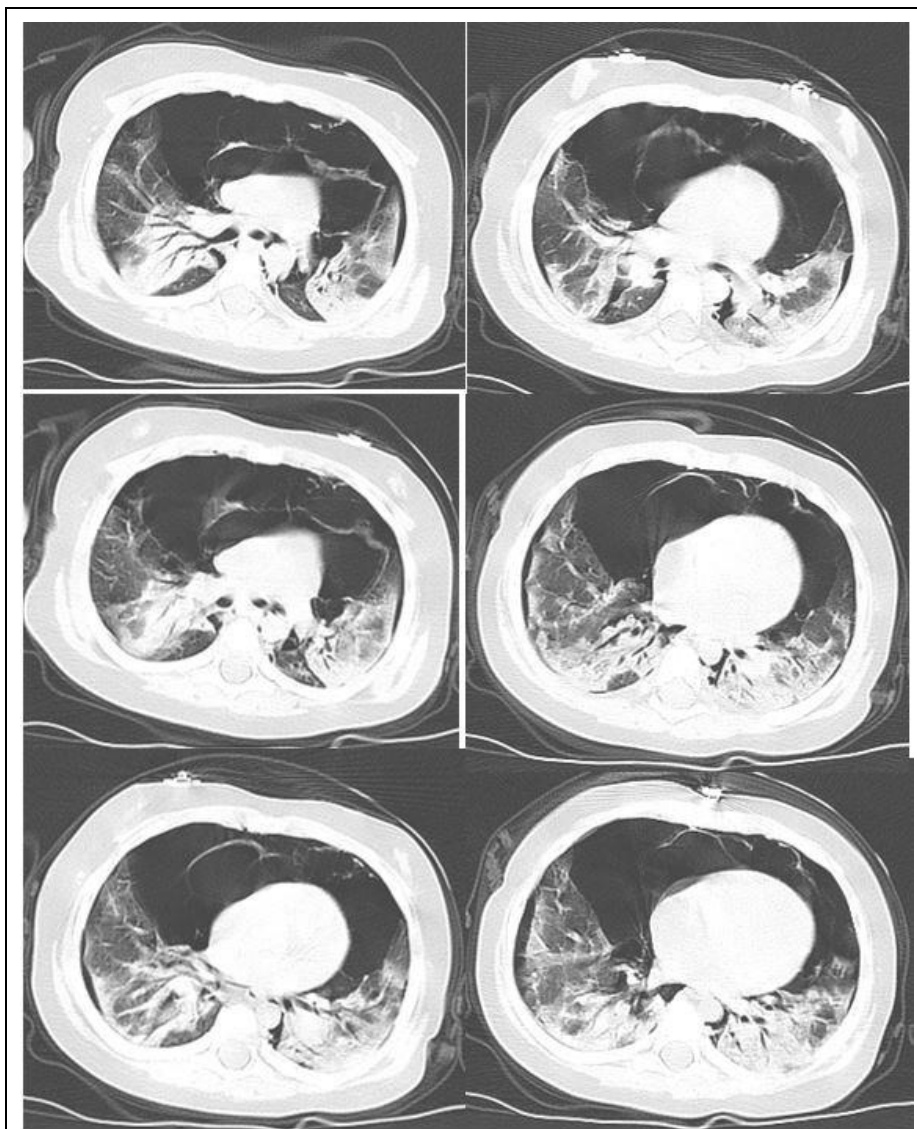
CT scan of chest showing pneumothorax bilaterally.
